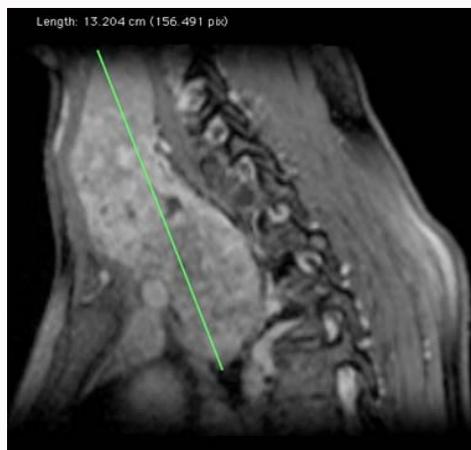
Sagittal MRI plane.
